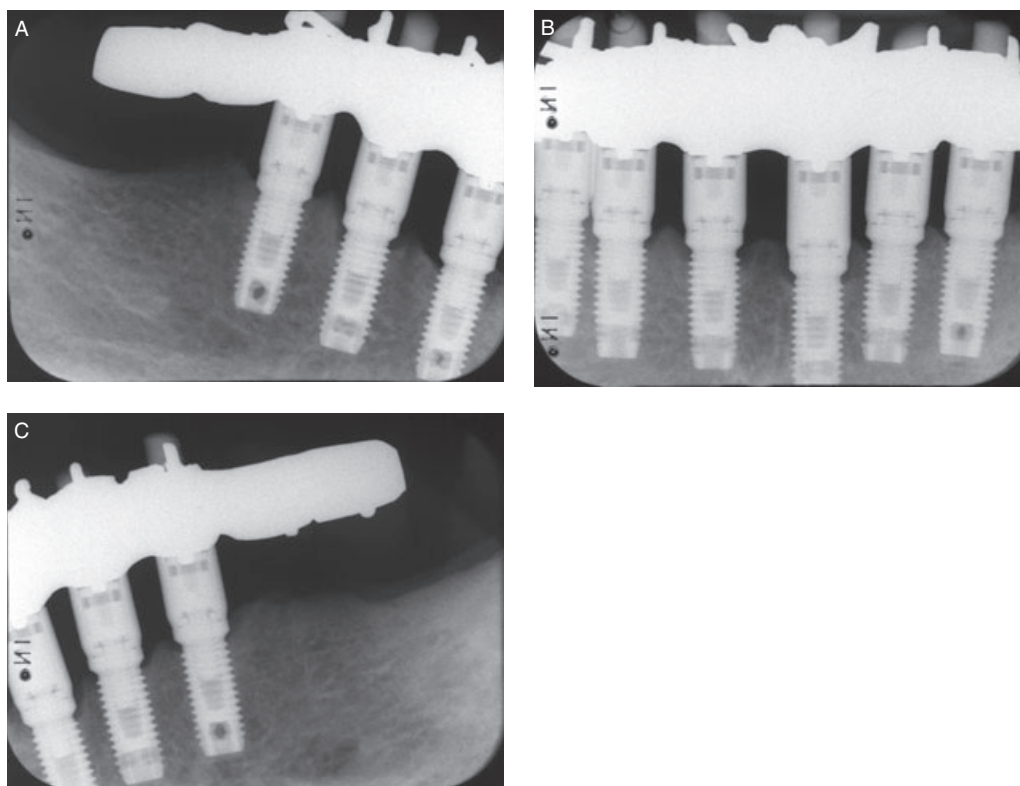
Eighty-three-year-old man who at the age of 59 was treated with six mandibular implants. Radiographs 24 years after treatment demonstrate good marginal bone level.
